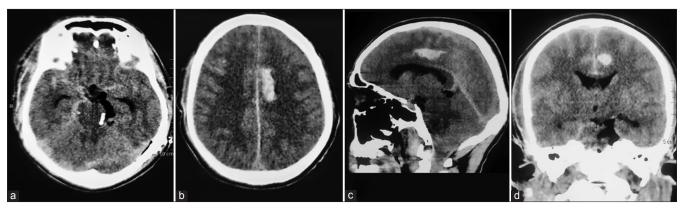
(a-d) Immediate postoperative computed tomography scan of the brain suggestive of no hematoma at the operated site but a remote left parafalcine frontoparietal intraparenchymal bleed.
